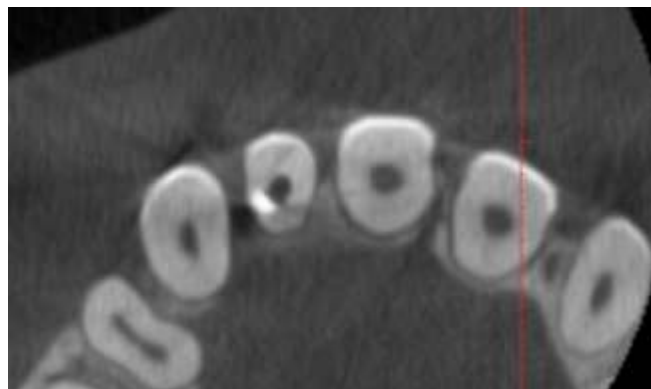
Communication between the perforation and the lesion on an axial CBCT view
